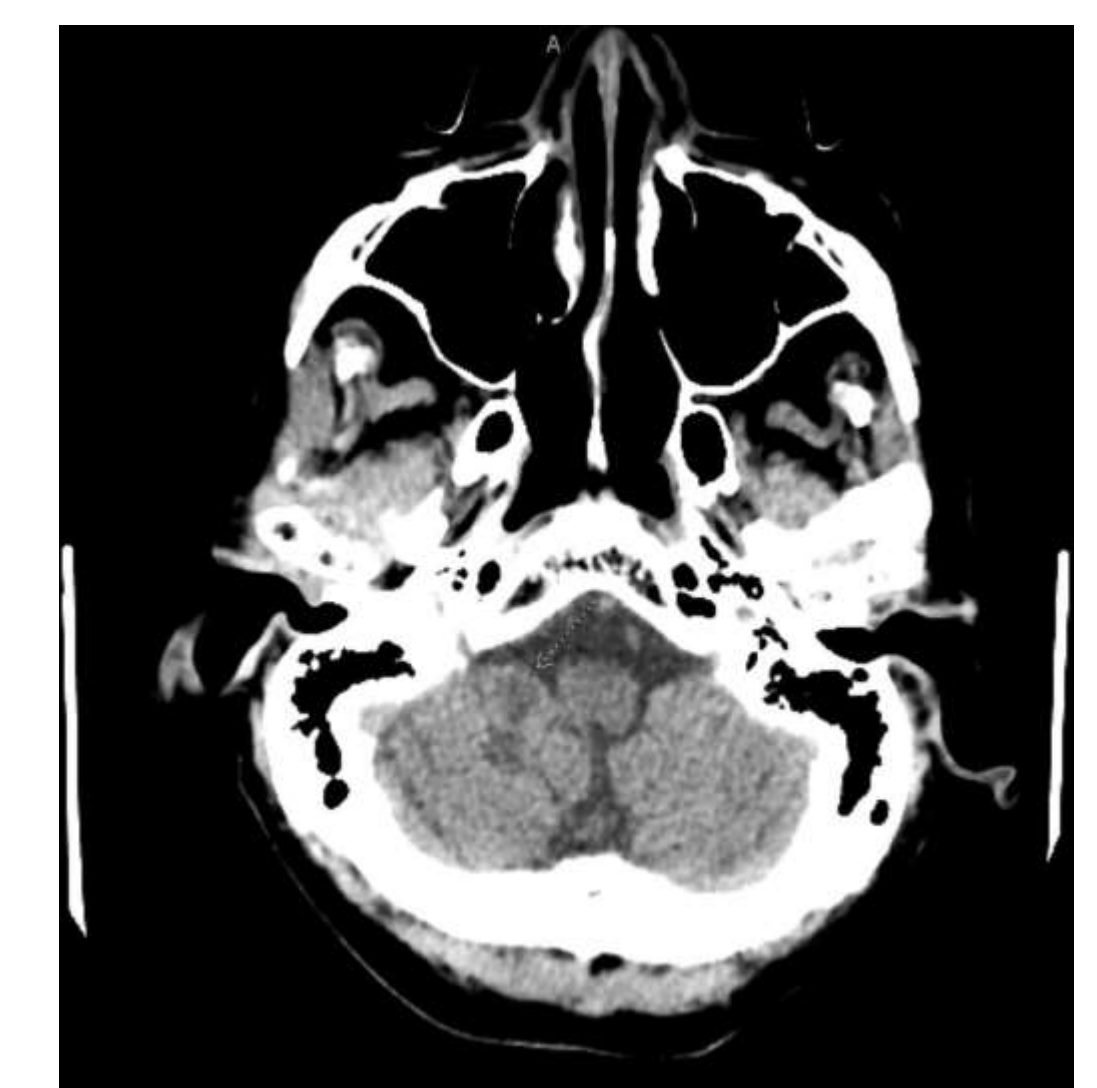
Computed Tomographic image of right inferior cerebellar infarct
